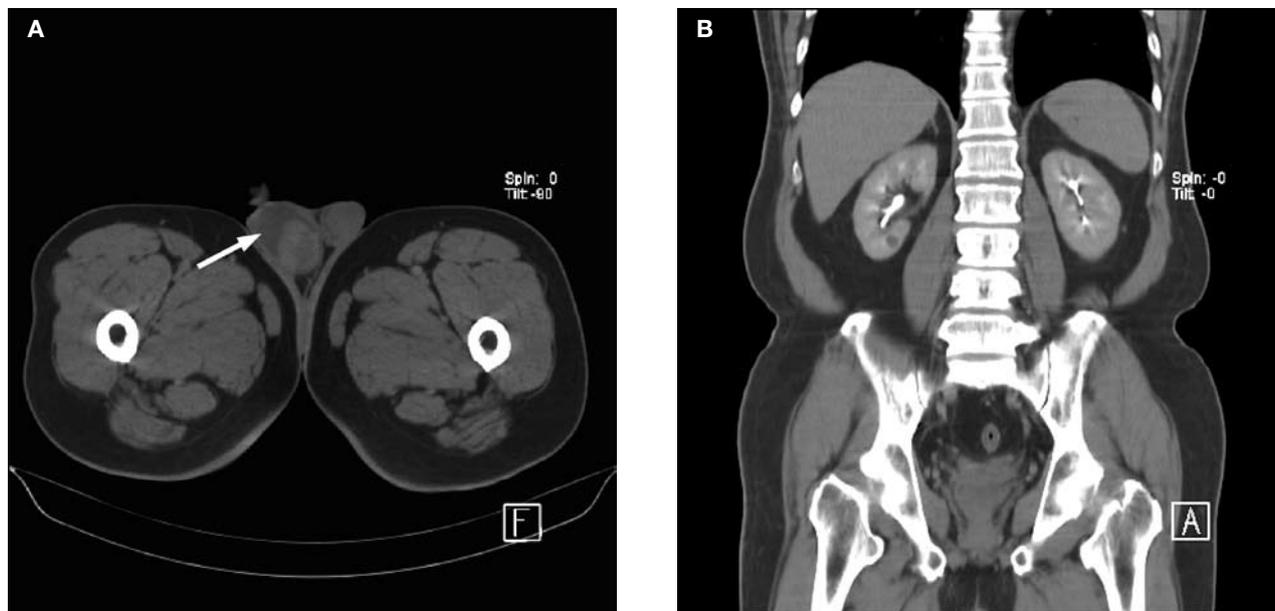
Computed tomography scans showing (A) a right testicular tumor involving the epididymis and a hydrocele (arrow); and (B) normal appearing kidneys, consistent with the clinical picture of isolated tuberculous epididymitis.
